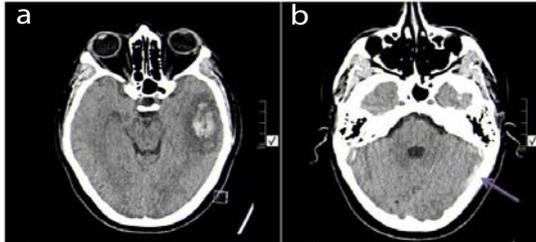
(a) Initial unenhanced CT brain showing moderate size left temporal intracerebral hemorrhage. (b) Left transverse sinus is hyperdense (arrow) in keeping with acute thrombus.
